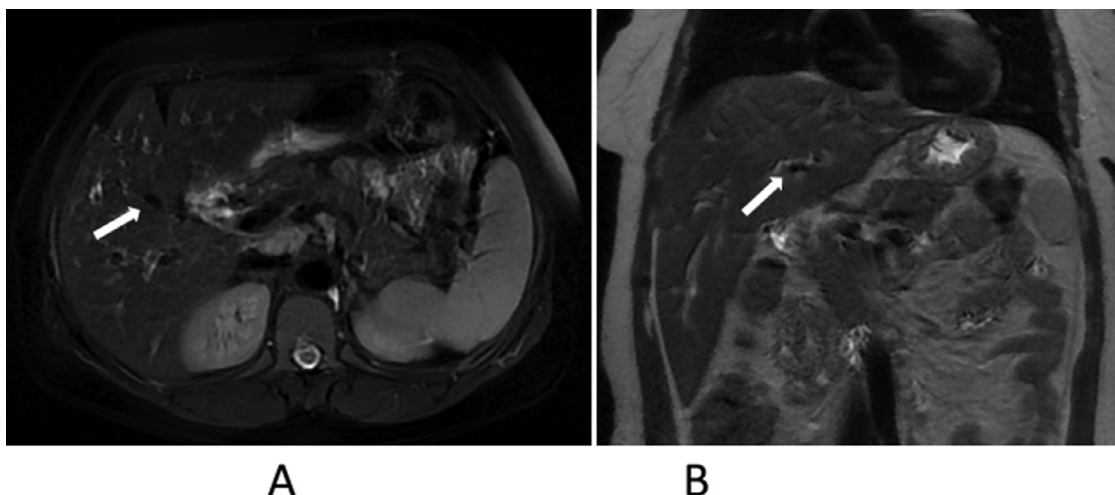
Axial sections of a Bili MRI in T2 (A), T1 (B and C) and 3D MRCPR (D) sequences showing intrahepatic bile duct (IHBD) microlithiasis in asignal, predominating at the level of segment V (arrows).
